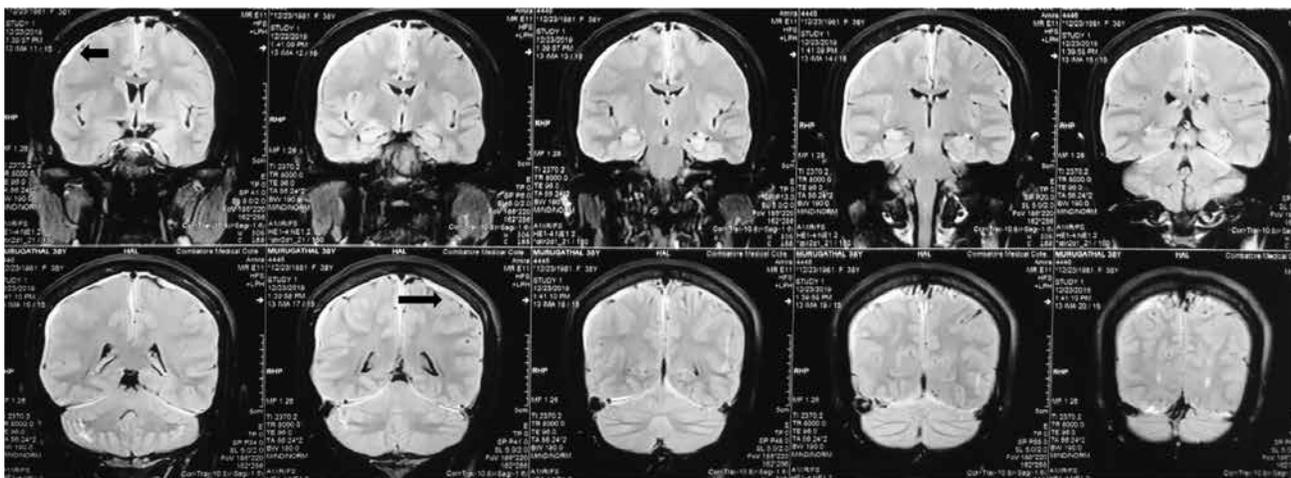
T2 Flair coronal section of MRI of brain - Bilateral subdural hygroma.
